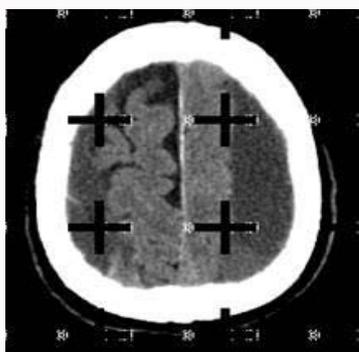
Stereological measurement of the TICV and CSDH areas have been shown in axial CT view of the 77 year-old male patient.
